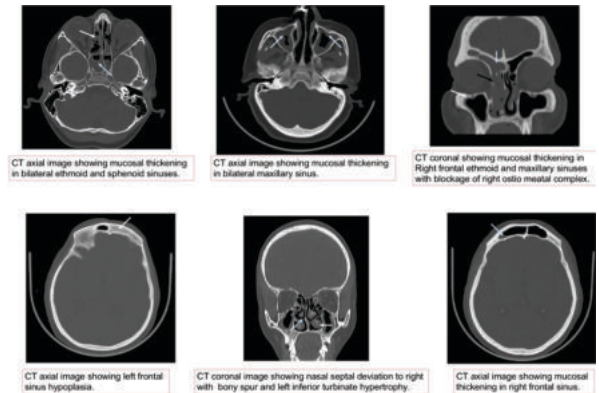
CT images in bone window showing PNS and Nasal cavity anatomical variations.
